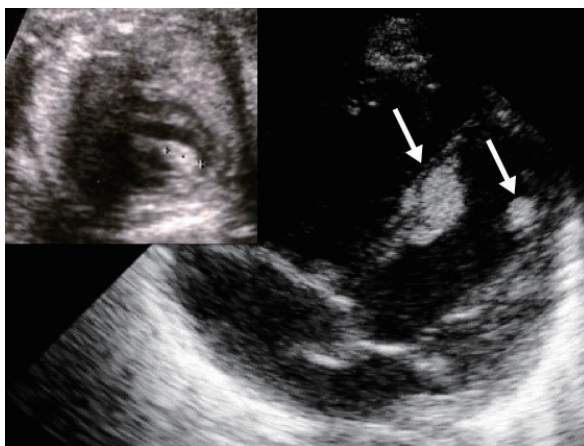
Two-dimensional echocardiographic findings of left ventricular tumors during fetal (inset) and neonatal periods.
